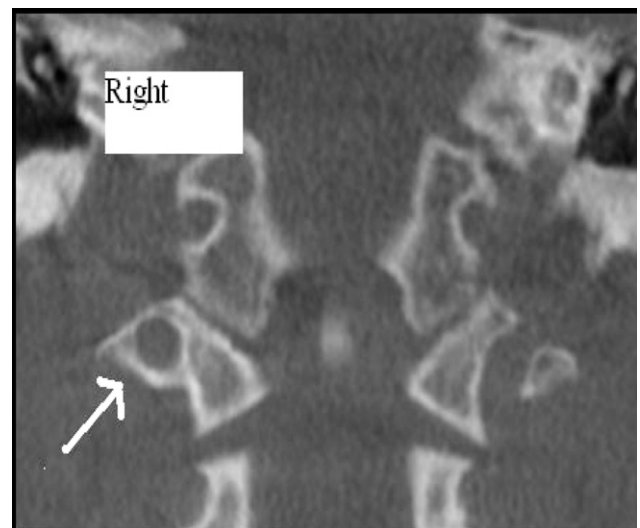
Cone beam CT viewed in the coronal plane reveals a complete Class 4 ponticulus lateralis on the right side of Class 1, indicated by the arrow. The left side is normal. The patient is a 14-year-old white female.
